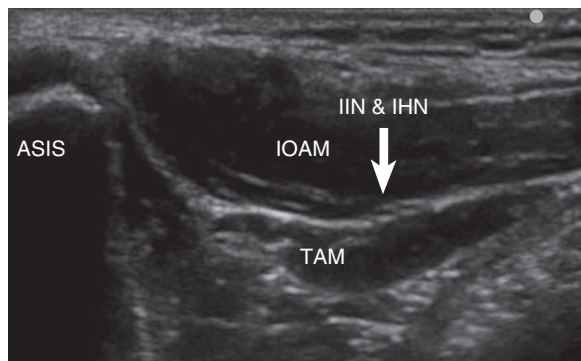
Transverse ultrasound scan of the ilioinguinal and iliohypogastric nerves (IIN and IHN) medial to the anterior superior iliac spine (ASIS). IOAM, internal oblique abdominal muscle; TAM, transversus abdominis muscle. Only the aponeurosis of the external oblique abdominal muscle above the IOAM is visible in this scan at that level.
